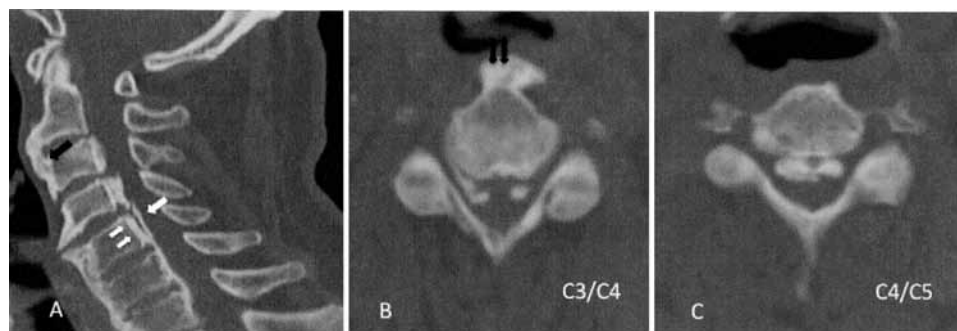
Findings of DISH and OPLL can commonly be found in the same patient as seen on this preoperative CT scan. A: Sagittal midline CT demonstrates ossification of both the ligaments and soft-tissue ventral to the vertebral bodies (black arrow); double white arrows indicate the first layer of ossification and the single white arrow indicates the second layer. B and C: Axial images showing the 2 layers of bone formation as well as ossification ventral to the C-3 body consistent with DISH (arrows, B).
